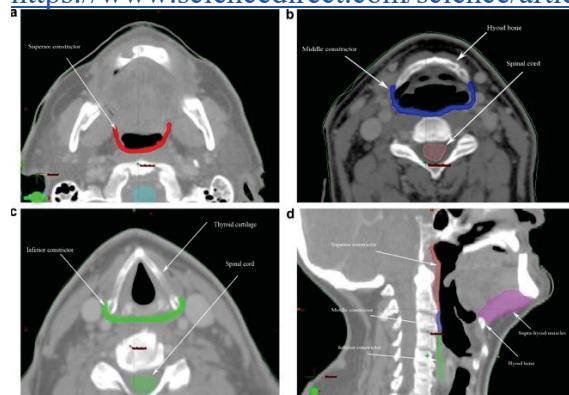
From Bhide et al (2009): Each of the pharyngeal constrictors was outlined as an arch-shaped structure with concavity facing anteriorly, in line with the mucosa (a-c). Posterior border of each of the muscles was the pre-vertebral muscle. Pharyngeal mucosa lining the muscles was included in outlines as it is quite thin and difficult to exclude with great accuracy with currently available CT images. Superior constrictor was outlined from the base of the skull up to the superior end of hyoid. Middle constrictor was outlined from the superior end to the inferior end of the hyoid bone. Inferior constrictor was outlined from the inferior aspect of hyoid to inferior end of cricoid cartilage. A sagittal view of all of the outlined pharynx is shown (d).
